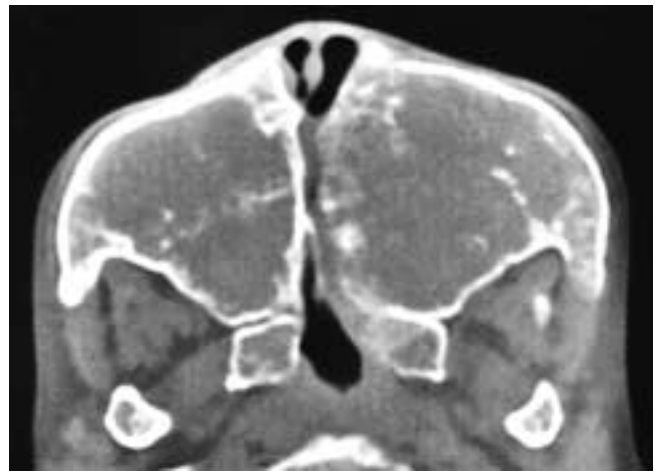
Axial CT scan at a wide window setting shows a markedly expanded maxilla with no development of the maxillary sinuses. The surrounding cortical bone is intact. The central portions of each maxilla are filled with expanded marrow. This patient had thalassemia.
